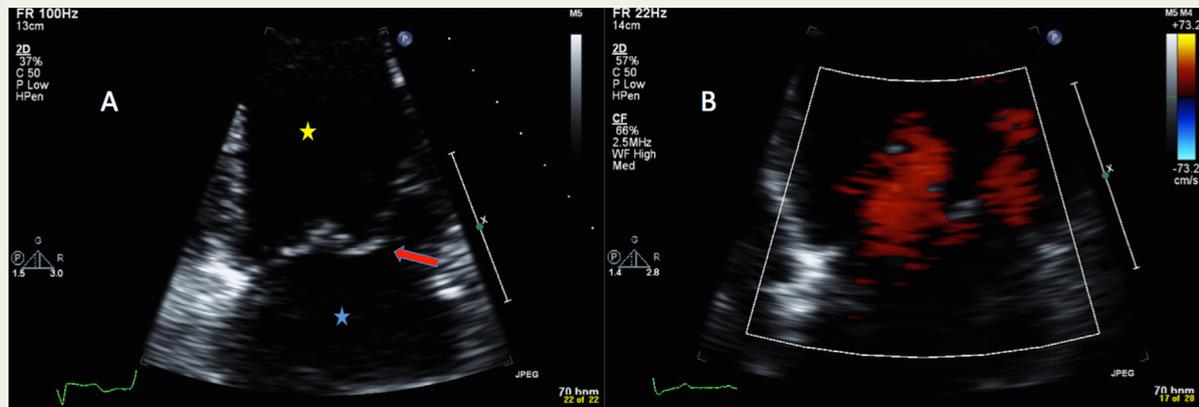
Apical 4-chamber view. A shows the left atrium (blue star), left ventricle (yellow star) and mitral valve (red arrow). In B, colour Doppler interrogation of the mitral valve during diastole demonstrates two parallel inflow jets.
